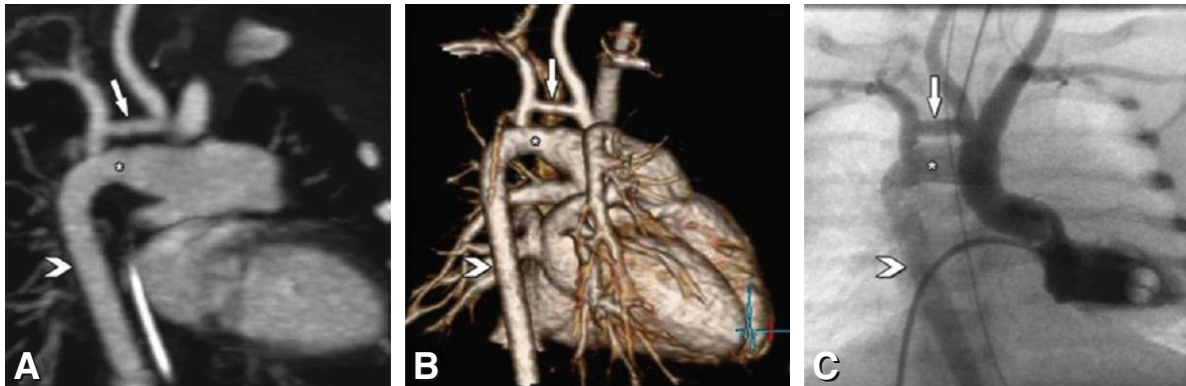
Hypoplastic aortic arch (*arrow*) and large persistent ductus arteriosus Botalli (*asterisk*) in a 2-day-old child prenatally diagnosed with a cardiac malformation. On a double oblique maximum intensity projection (Panel A) the large persistent ductus arteriosus and the hypoplastic aortic arch (*arrow*) are shown. The persistent ductus arteriosus connects the main pulmonary artery and the descending aorta (*arrowhead*), which is normal. For operative planning the CT images were additionally presented to the surgeon as three-dimensional volume renderings (Panel B). Panel C presents the corresponding image from left ventricular catheterization
